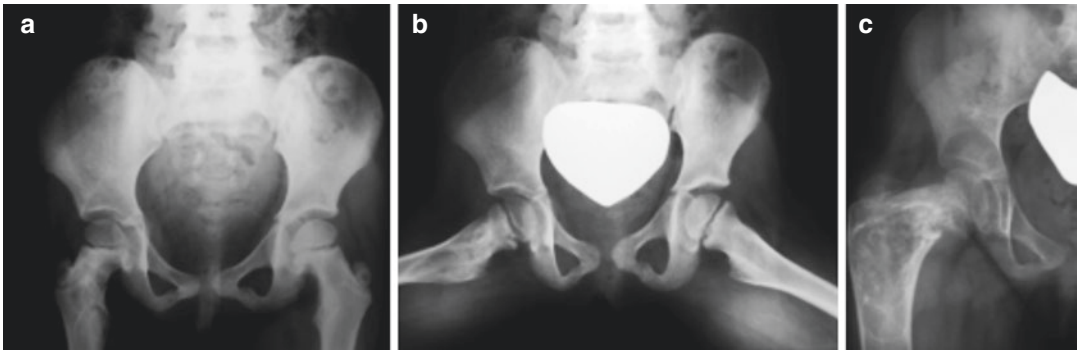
AP radiograph of the pelvis demonstrating a child with fibrous dysplasia of the hips (a and b) that progresses to a “shepherd’s crook” deformity over three years time (c)
